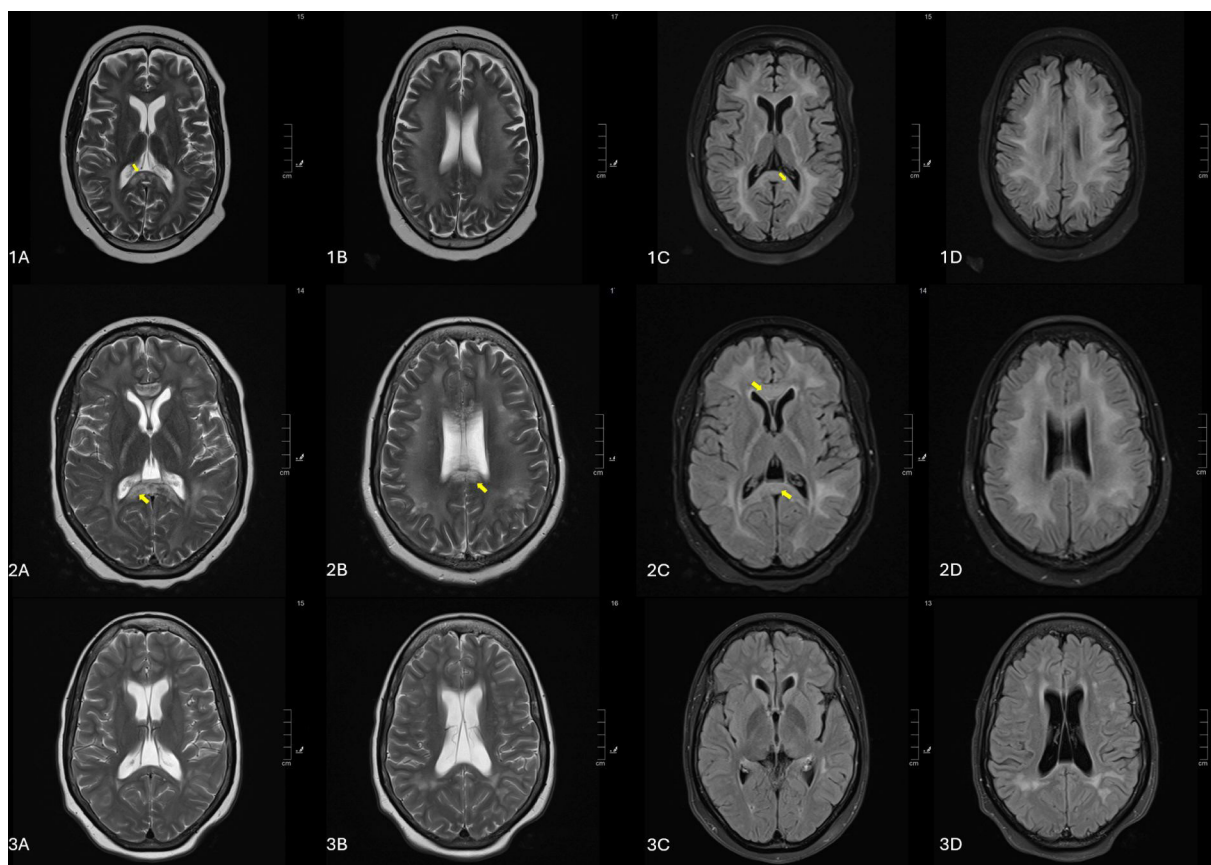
MR images of the brain of patient 1 (image 1) and patient 2 (image 2) during a relapse: axial T2 (A, B) and T2 fluid-attenuated inversion recovery (C, D) images show diffuse white matter hyperintensities involving the bilateral hemispheres and the splenium and genu of the corpus callosum (arrows). Image 3 (patient 2 post treatment): axial T2 (A, B) and T2 fluid-attenuated inversion recovery (C, D) images show significant resolution of previous white matter hyperintensities seen in image 2.
